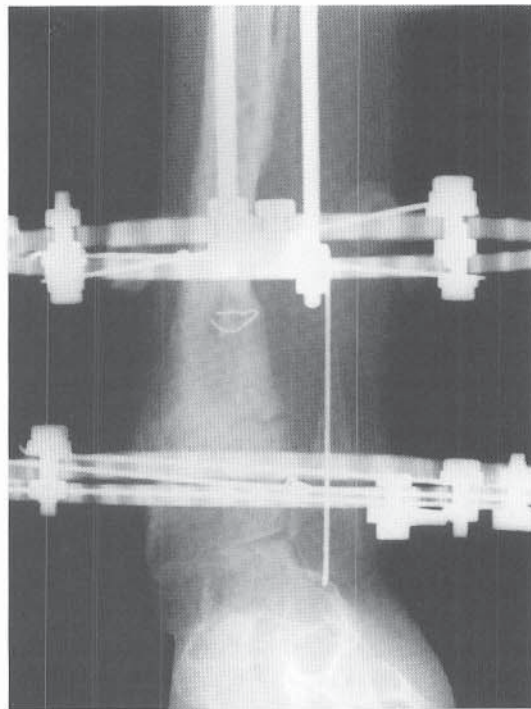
A and B, Radiographic appearance in a 13-year-old girl with neurofibromatosis type 1 who had undergone two intramedullary rod placements (at ages 2 and 6) and an Ilizarov procedure (at age 12) to obtain this straight tibia. Although she had poor foot function, she was ambulatory without a brace. C and D, A pathologic fracture at age 14 years 6 months was treated by another frame to correct deformity distally and compress via a proximal corticotomy-bone transport. E, Appearance after proximal lengthening and step-cut compression at the distal fracture site (*arrows*). F and G, After 4 months the proximal corticotomy had healed but the distal site remained ununited, with valgus and procurvatum deformities. H, A new corticotomy was made distal to the nonunion, with provision for angular correction of valgus.
